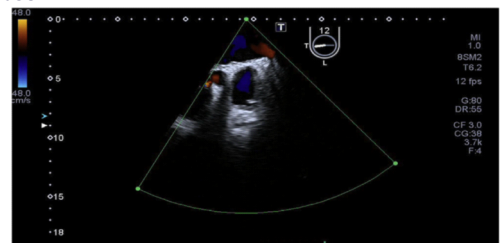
Trans-oesophageal echocardiography with 2D and color Doppler shows a complete absence of residual flow across LAA and no residual pouch after pericardial patching.
